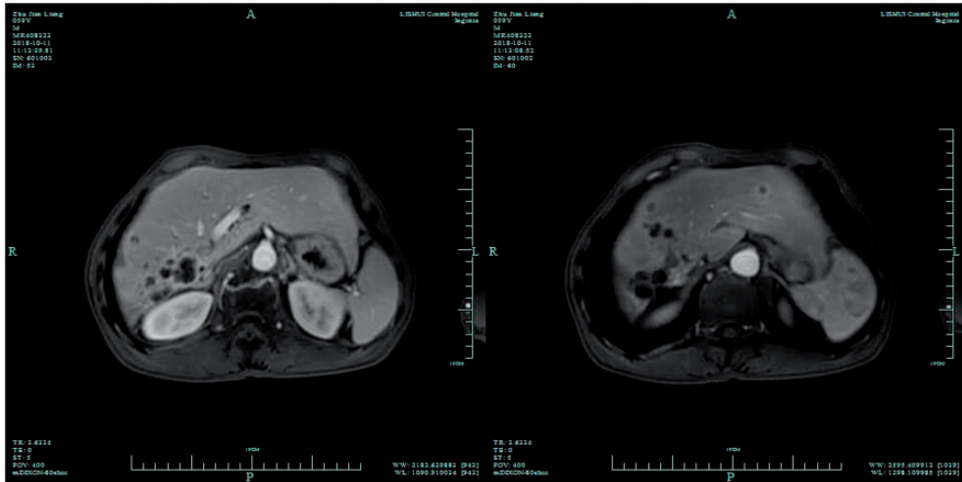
One-year postoperative magnetic resonance imaging. Multiple liver masses were present, and the lesions demonstrated significant enhancement in the arterial phase.
